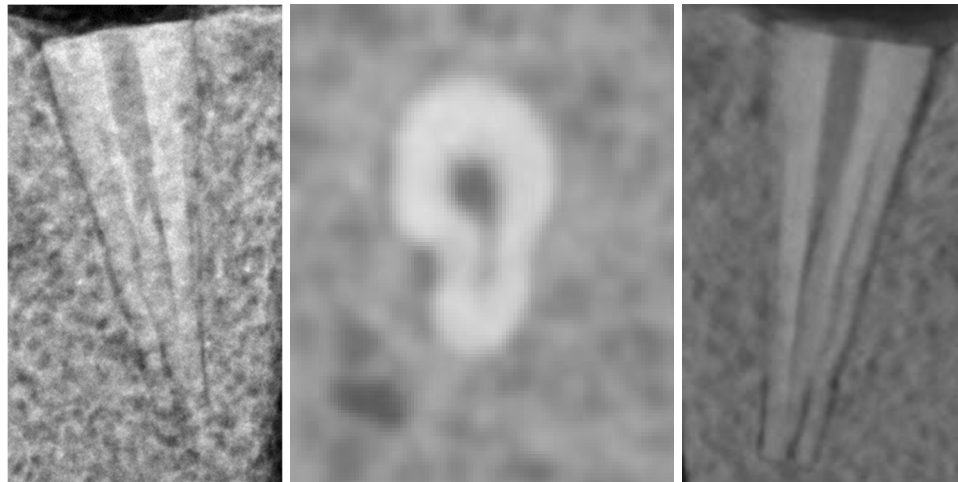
Figure #24: Unobtured & fracture absent sample (X7) with Type IV & C-shape anatomy in the apical third. The CBCT axial slice (middle) reveals no fracture and a radicular concavity that results in a radiolucent defect confused as a fracture in the tomosynthesis image (right)
